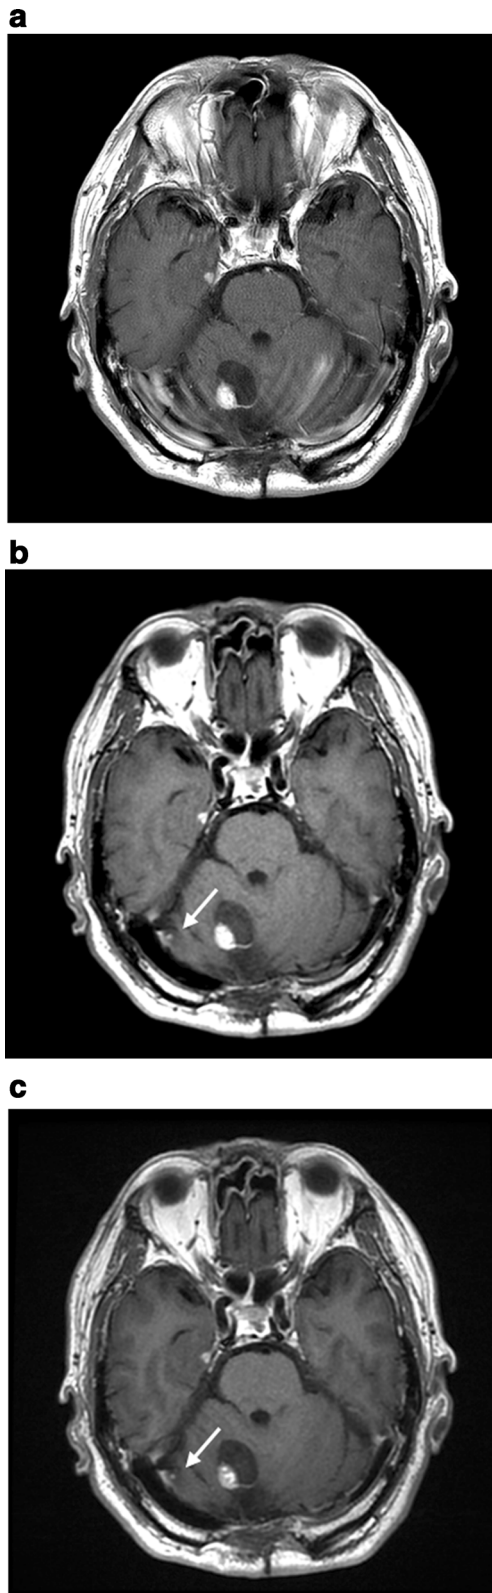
(a) Contrast-enhanced T1W-SE image, (b) contrast-enhanced BB Cube image, and (c) contrast-enhanced BB Cube-FLAIR image from a 63-year-old patient with recurrence of hemangioblastoma. In all images, a neoplastic cyst with enhanced mural nodule in the right cerebellar hemisphere could be found. However, the enhanced small nodule (arrow) could be identified in BB Cube and BB Cube-FLAIR, but not in T1W-SE due to flow-related artefacts
